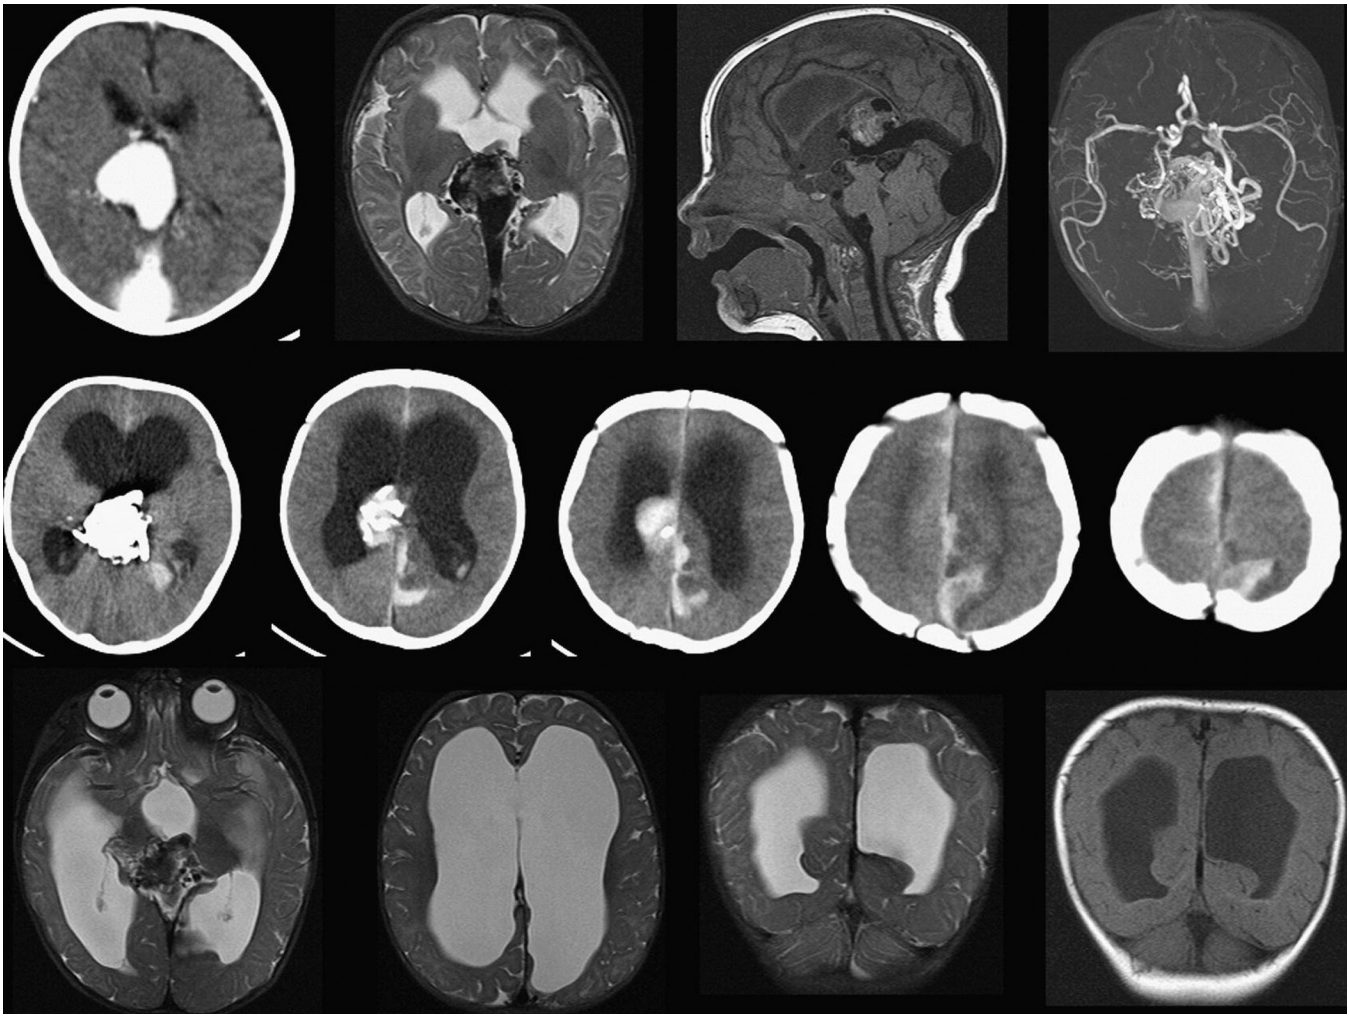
Neonatal Vein of Galen Malformation and Intraventricular Hemorrhage. A 5-day-old female born at 38 weeks was noted to be drowsy with poor feeding. She had signs of cardiac failure. A computed tomography (CT) scan (*top left*) demonstrates vein of Galen aneurysmal malformation, which was partly treated by transarterial glue embolization without complication but with significant residual arteriovenous shunting (MR images, *top row*). Following a 2nd embolization procedure, there was acute clinical deterioration with signs of raised intracranial pressure (*middle row*). CT shows acute intraventricular hemorrhage and hydrocephalus, and a left parieto-occipital lobe low-density lesion (*middle*, images 1-3) with adjacent subarachnoid and subdural hematoma (*middle*, images 4-5). Some linear hyperdensity was believed to be due to thrombus within the persistent falcine sinus (*middle*, images 4-5). Follow-up imaging shows maturation of the focal left parieto-occipital lesion in keeping with an infarct (*bottom row*), which is probably venous in origin. (With permission from Gunny RS, Lin D. Imaging of pediatric stroke. *Magn Reson Imaging Clin North Am*. 2012;20:1-33.)
